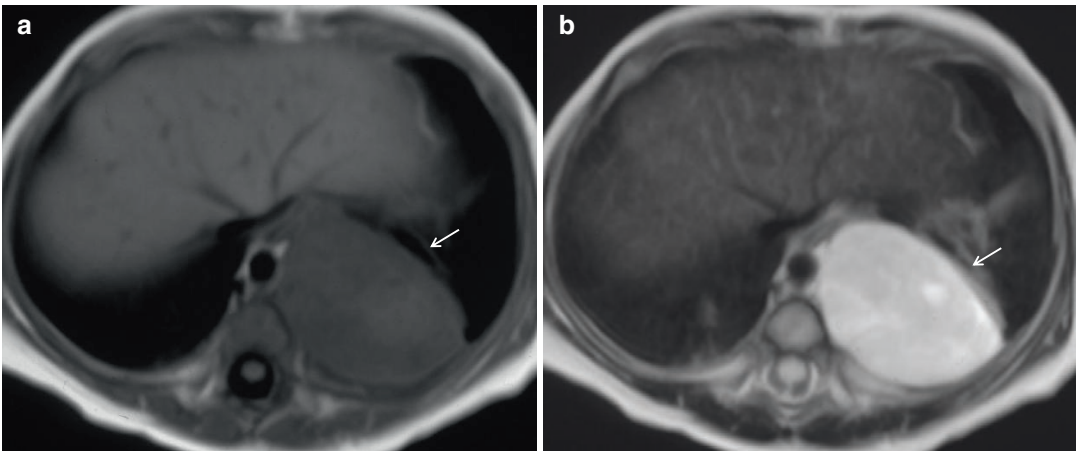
Neuroblastoma. T1-weighted (a) and T2-weighted (b) axial images show a left paravertebral mass (arrows). The mass shows low signal intensity on T1-weighted image and high on T2-weighted image
